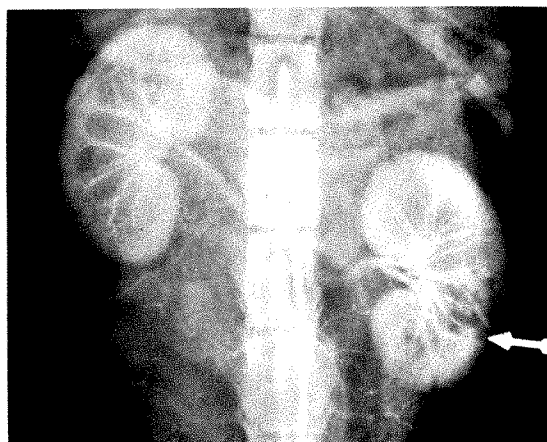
Case II. Roentgenogram following extensive trauma across ventral surface of lower half of kidney. Small seriation is noted on nephrogram in lower pole. Overlying normal parenchyma obscures the lesion to great degree. Defects are best seen in cross section rather than *en face*.
